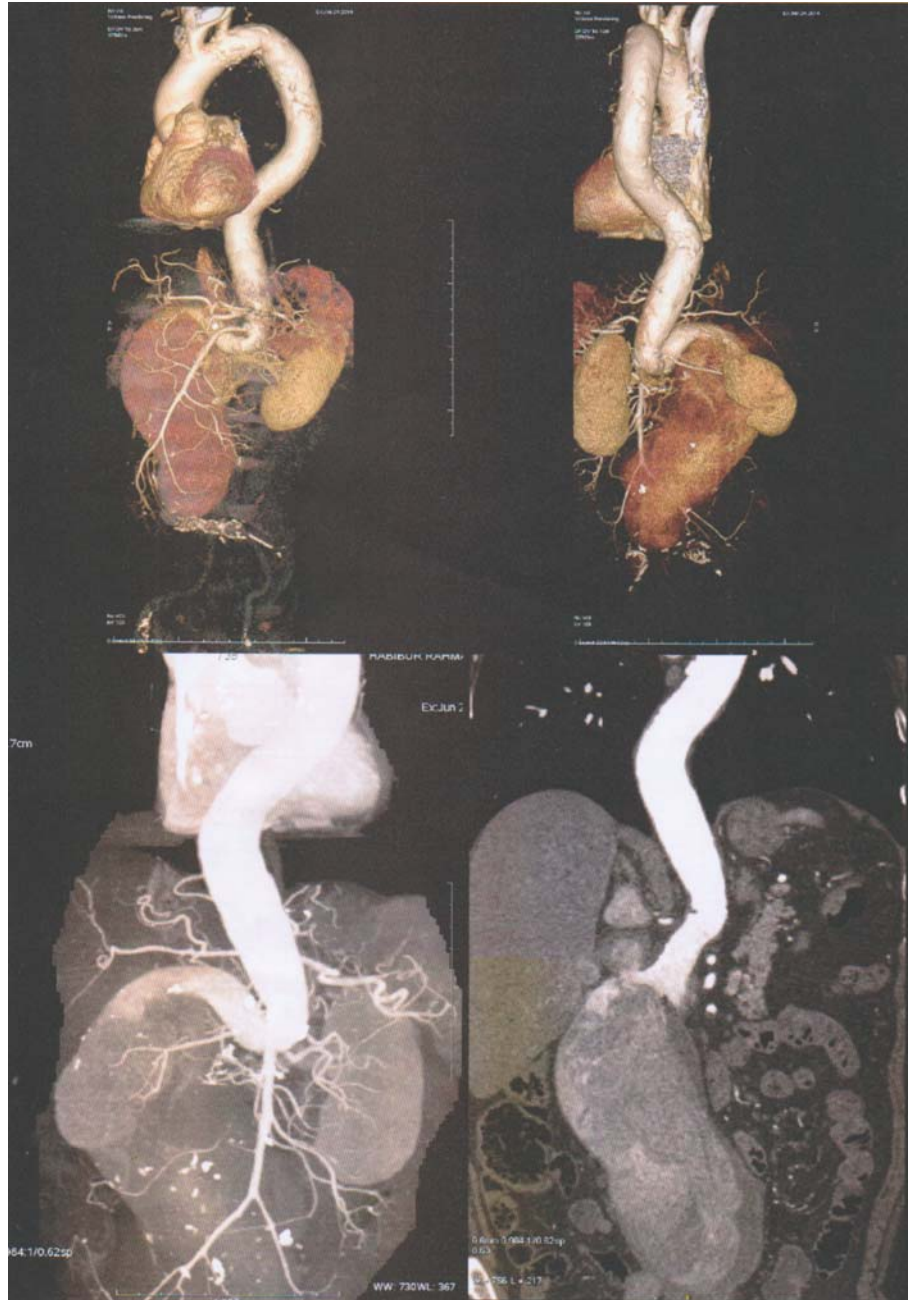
CT scan of the abdomen showing a giant infrarenal fusiform aortic aneurysm. No contrast is seen within the lumen of aneurysm suggesting complete thrombosis.
